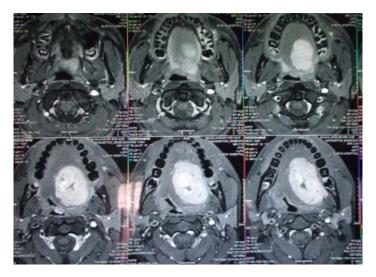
MRI of head showing heterogeneously enhancing mass lesion arising from left side of tongue and crossing the midline just above the sublingual space
